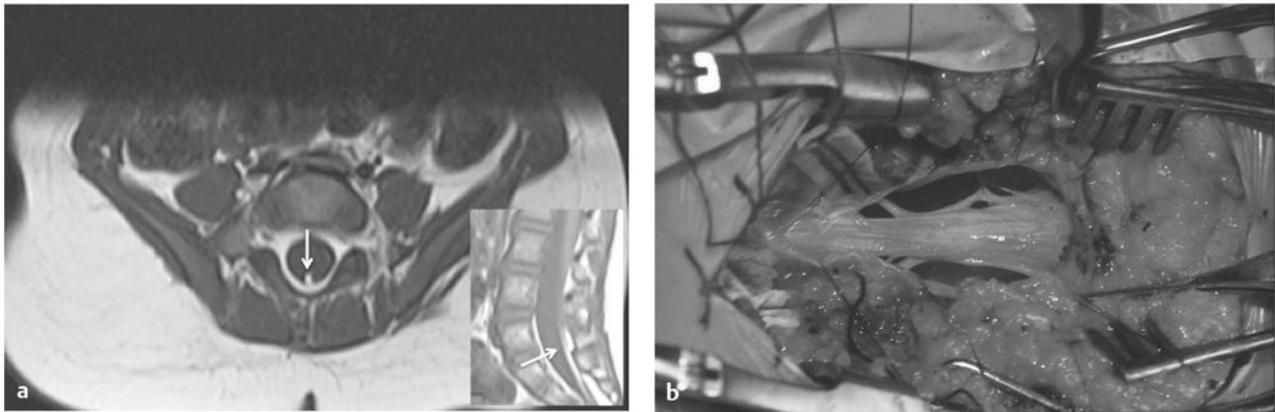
(a) Transverse and midsagittal magnetic resonance images of a small infant with a tethered spinal cord resulting from a tight filum terminale. The conus is abnormally low (below L3), and the filum is enlarged and infiltrated with fat (arrows). (b) Thick, tethering filum terminale. Roots ascend to reach their exit foramina.
